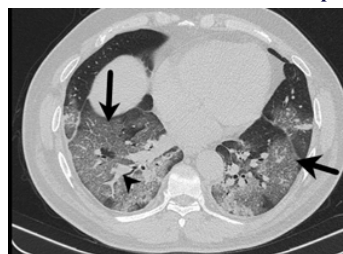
Axial nonenhanced chest CT image shows ground-glass opacities, with superimposed interlobular and intralobular septal thickening i.e. Crazy-paving pattern (arrows) in the both lower lobe in a 50-year-old man with COVID-19. Note adjacent vascular dilation (arrowhead).
